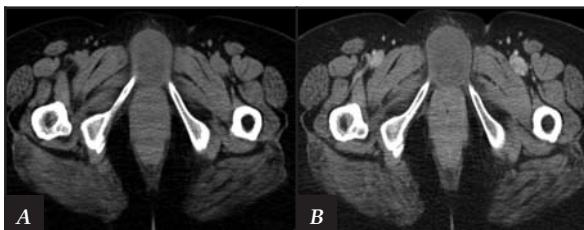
Axial non-contrast (A) and contrast enhanced (B) computed tomography images demonstrate the well-circumscribed nature of the cyst with no enhancement and homogeneous contents within.
